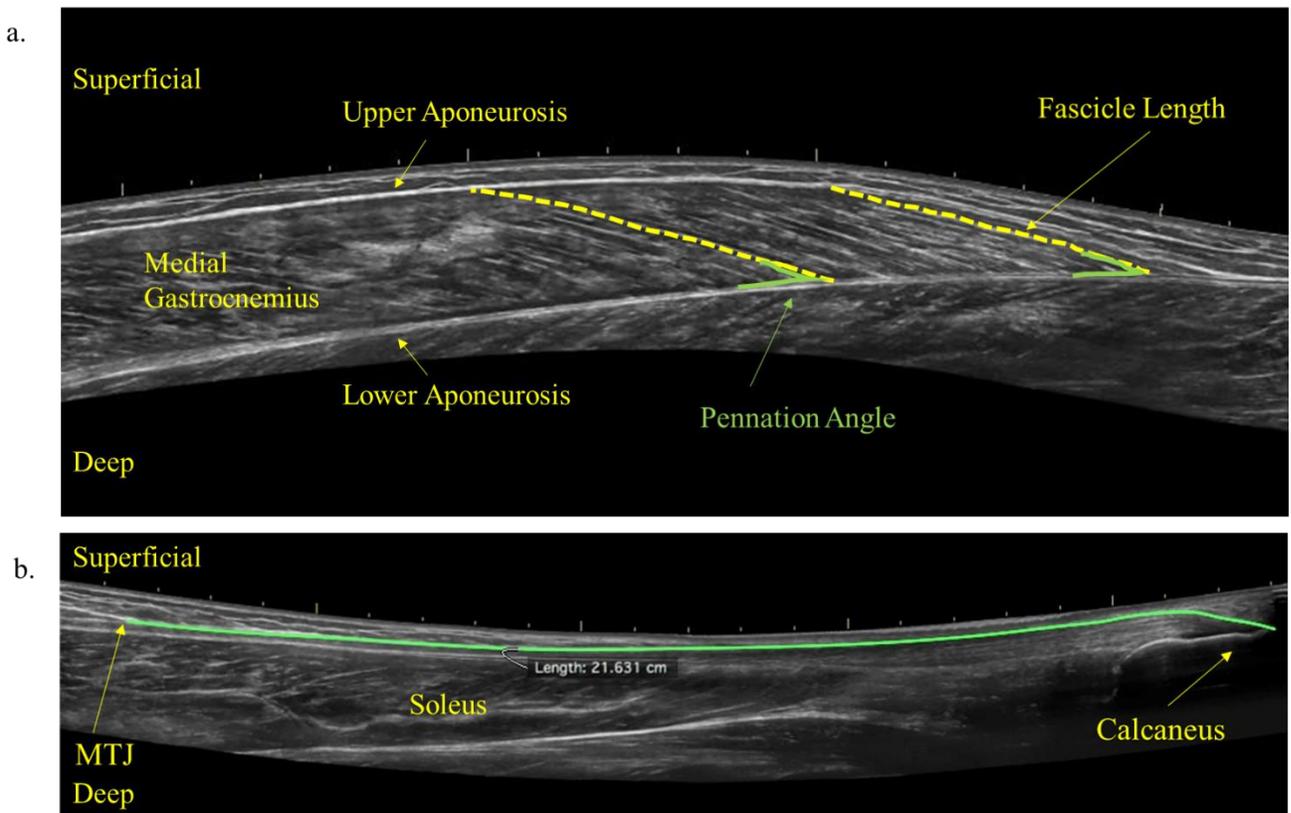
Representation of ultrasound images and measurements of the muscle fascicles and pennation angles (a) and the Achilles tendon (b). MTJ is the muscle tendon junction. Muscle image (a) was collected with a LOGIQview scan from the MTJ to the popliteal crease. Tendon image (b) was collected from the tendon insertion on the calcaneus to the MTJ. Both images were captured with a ML6-15 probe (4.5-15.0 MHz linear array, 13 x 58 mm foot print, 30 frames per second, 50 mm field of view, 8 cm depth of field LOGIQview, GE®)
